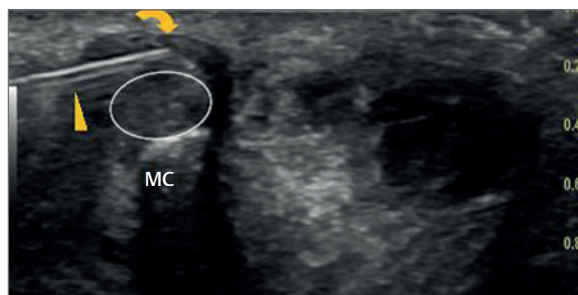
Ultrasound-guided injection of the tendon sheath of flexor pollicis longus at the level of the metacarpophalangeal joint of the thumb (MC). The needle (yellow arrowhead) may be seen approaching from the left of the image. The needle rests between the flexor sheath (yellow curved arrow) and the tendon itself (white oval). In this image the sheath measures approximately 1 mm in depth and demonstrates the accuracy of needle placement possible with ultrasound guidance.
